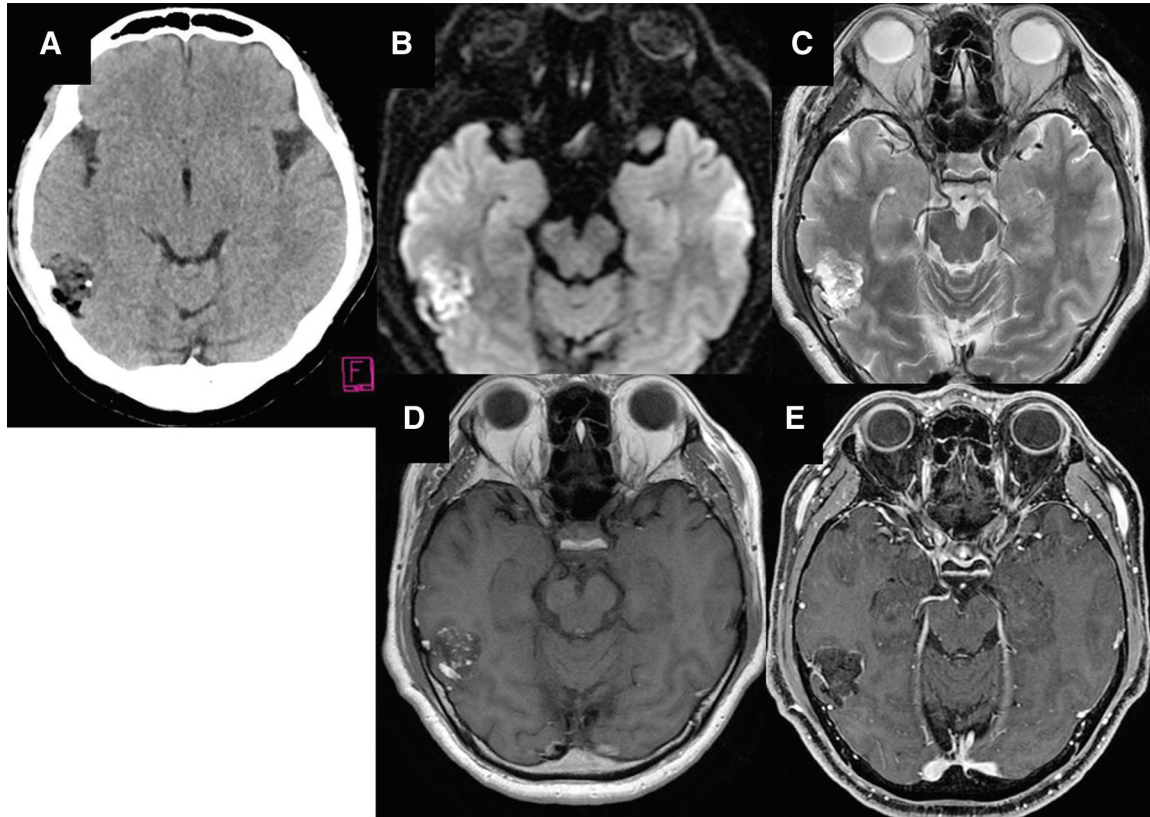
Preoperative neuroradiological examination. (A) Plain CT showing an iso-to-hypo-dense tumor in the right temporal lobe including a small calcified area. Preoperative MRI showing the tumor in the right temporal lobe. (B and C) The tumor appears as a heterogeneous hyperintense lesion on diffusion-weighted imaging (DWI) (B) and T2-weighted imaging (T2) (C). (D) T1-weighted imaging (T1) showing a hypointense lesion with a hyperintense spotty area. (E) Partial enhancement of the capsule seen on T1 after gadolinium administration (T1Gd+).
